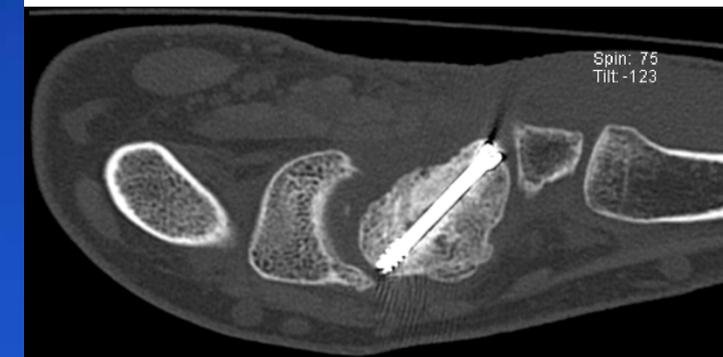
CT scan demonstrating union at both proximal and distal graft sites at 19 weeks post vascularized bone grafting.
